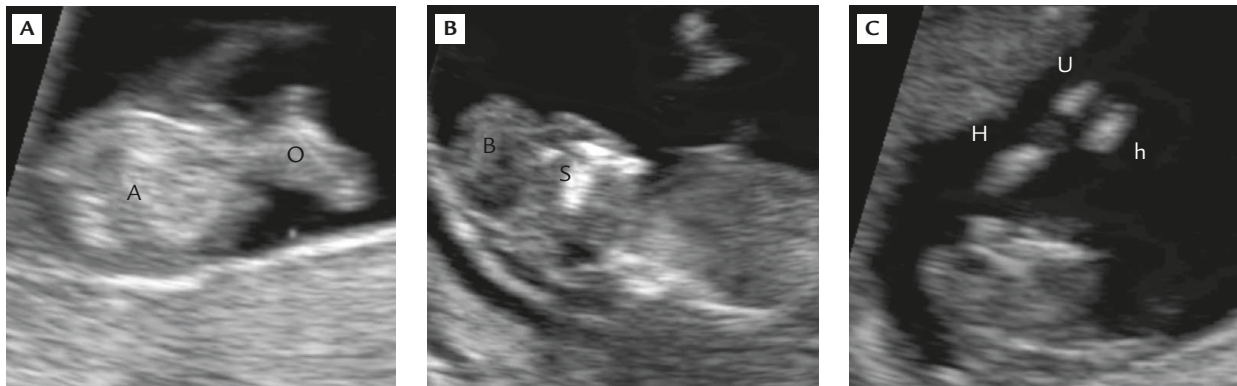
Prenatal ultrasound at 12 weeks' gestation shows: (A) omphalocele; (B) anencephaly; and (C) arthrogryposis of the upper limb. A = abdomen; O = omphalocele; B = brain; S = skull; h = hand; H = humerus; U = ulna.
